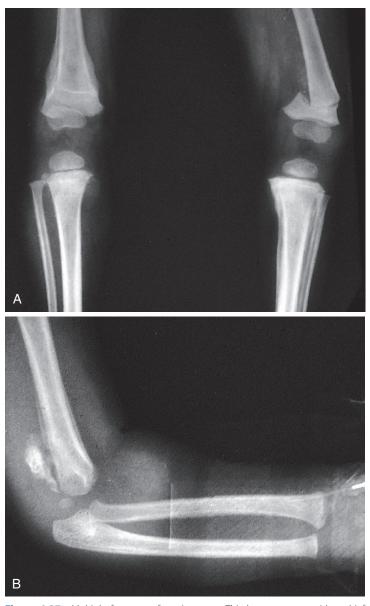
Multiple fractures of varying ages. This boy was seen with a chief complaint of refusing to bear weight. On examination, he was found to have marked swelling, tenderness, and crepitance over the distal left femur. A, Radiographic examination confirmed the presence of an acute transverse fracture and also revealed multiple additional fractures in various stages of healing. These include an old transverse fracture of the distal right femur with callus and subperiosteal new bone formation that is in the process of remodeling. Relatively new metaphyseal chip fractures are seen involving the right proximal tibia, and vigorous subperiosteal new bone formation encompasses the left tibia. B, On skeletal survey he was also found to have a healing fracture of the distal humerus with vigorous callus and subperiosteal new bone formation and considerable soft tissue swelling. Note that the cortices of his long bones are of normal thickness. No care had ever been sought for the older fractures. *(Courtesy Department of Radiology, Children's Hospital of Pittsburgh, Pa.)*
